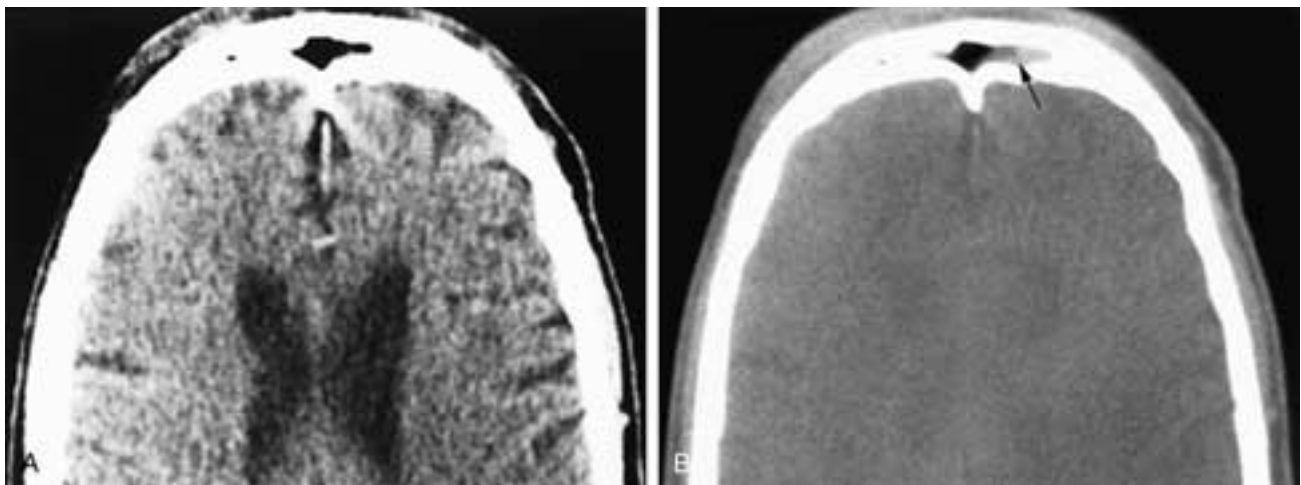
In A, an axial CT scan viewed at a "soft-tissue" window setting, the left frontal sinus appears well aerated. However, in B, inflammatory mucosal thickening in the left frontal sinus (*arrow*). This patient had a headache and acute sinusitis.
